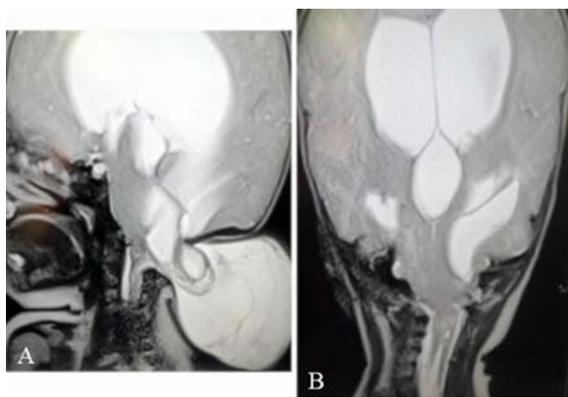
Preoperative MRI brain from sagittal view (A) and coronal view (B) revealed moderate to severe hydrocephalus, high cervical syringomyelia, large occipital encephalocele with relatively small amount of herniated brain tissue in the sac and dilated of occipital horn with downward herniation causing distortion of brain stem axis.
